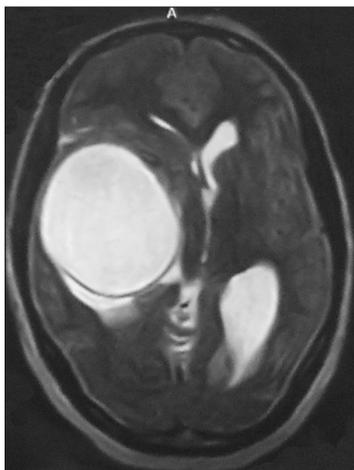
MRI T2W image of brain showing a CSF intensity cystic lesion in right temporoparietal region
